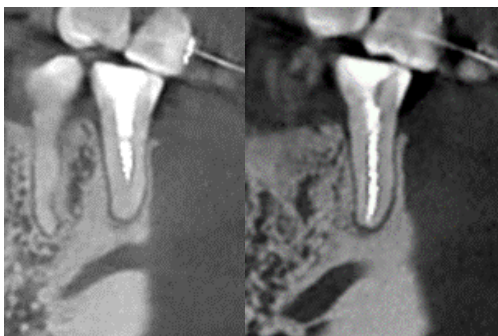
CBCT images after 8 months follow-up, tomography demonstrated bone healing around the apex of the second premolar
